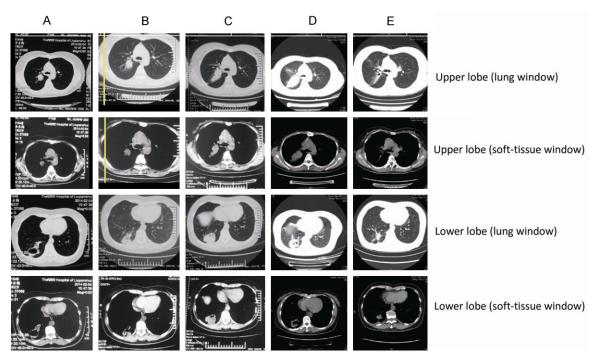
CT images showing the development of the lesions (a nodule in the upper lobe and a cavity in the lower lobe).
